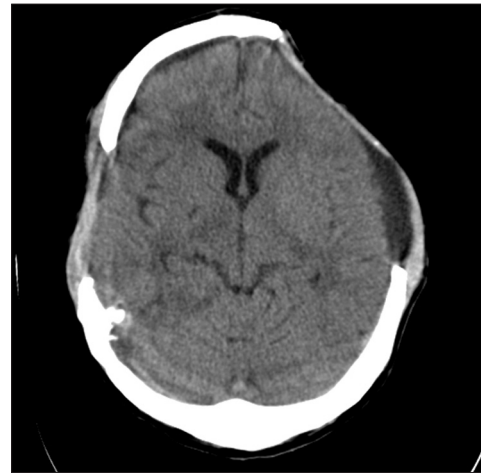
CT scan shows sinking skin flap at the 19th day after decompressive craniectomy
